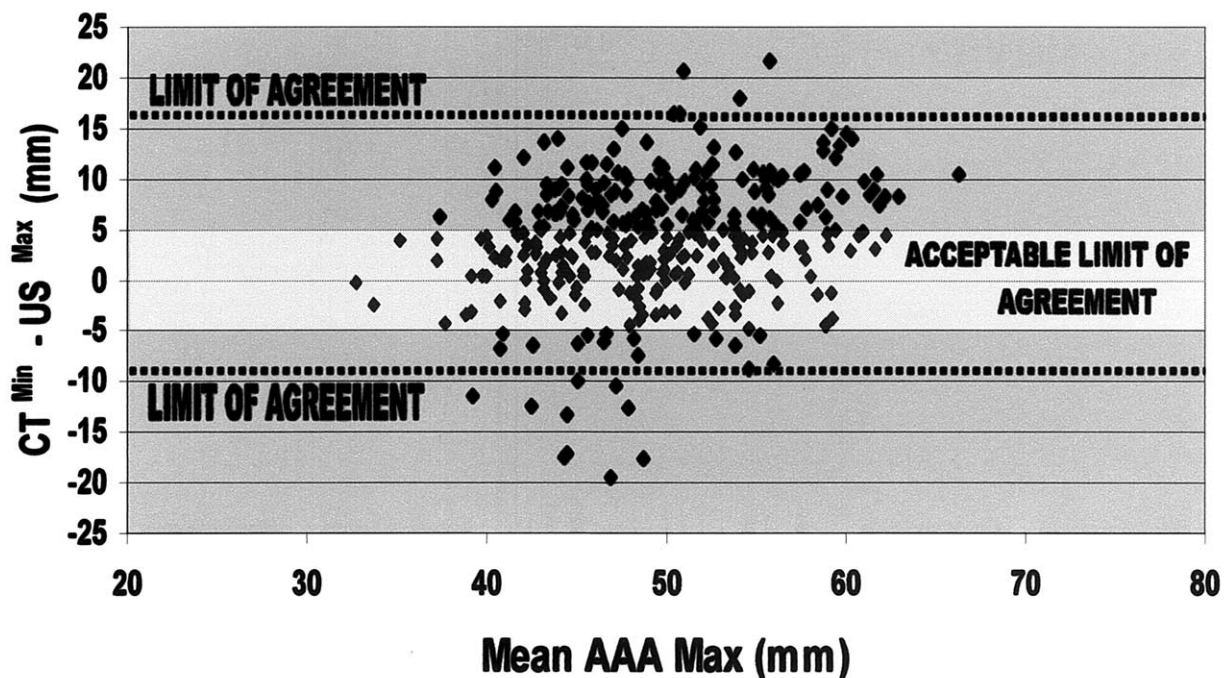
Limits of agreement (broken lines) between CT^{min} and US^{max} (-9.2 - 16.2 mm) compared with clinically acceptable limits of agreement (highlighted area) between CT^{min} and US^{max} (-5.0 - 5.0 mm).
